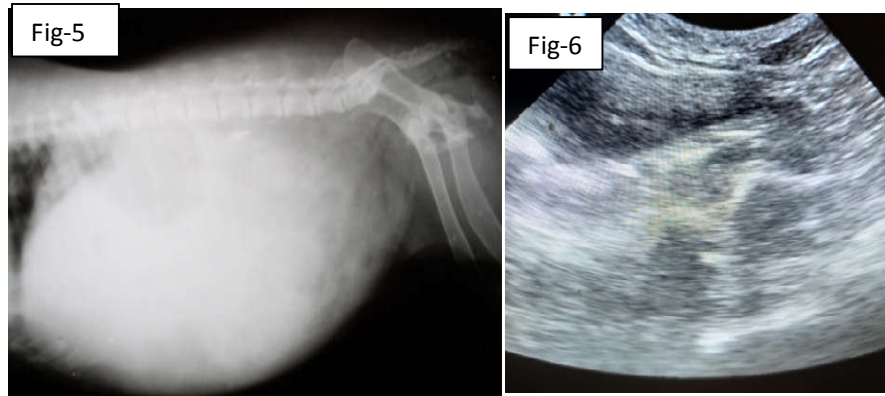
LATERAL VIEW OF ABDOMINAL RADIOGRAPHY AND SONOGRAPHY
